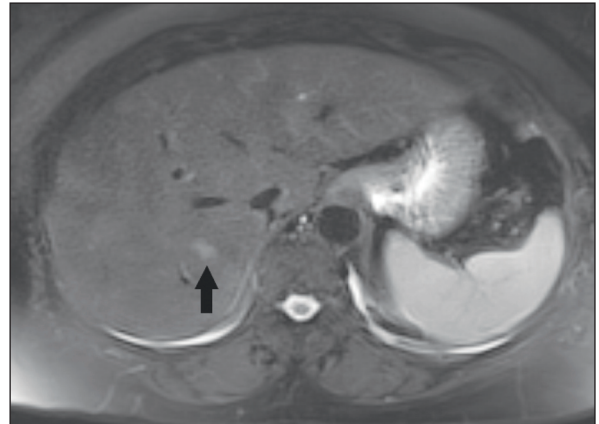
MRI images of multiple lesions in the liver.
